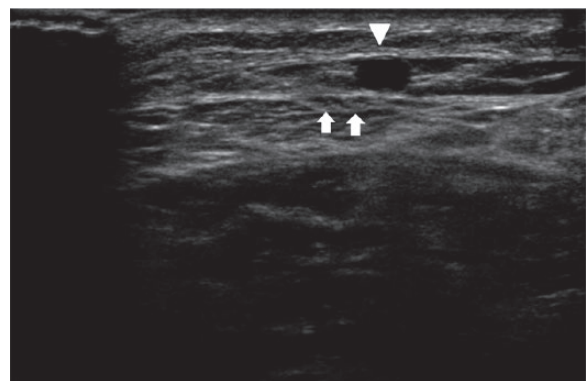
Ultrasonographic detection of the risk point: Sural nerve is divided into two cutaneous branches (arrows) and out of the saphenous compartment but cutaneous nerves are not 5 mm away from the small saphenous vein (arrow head).
